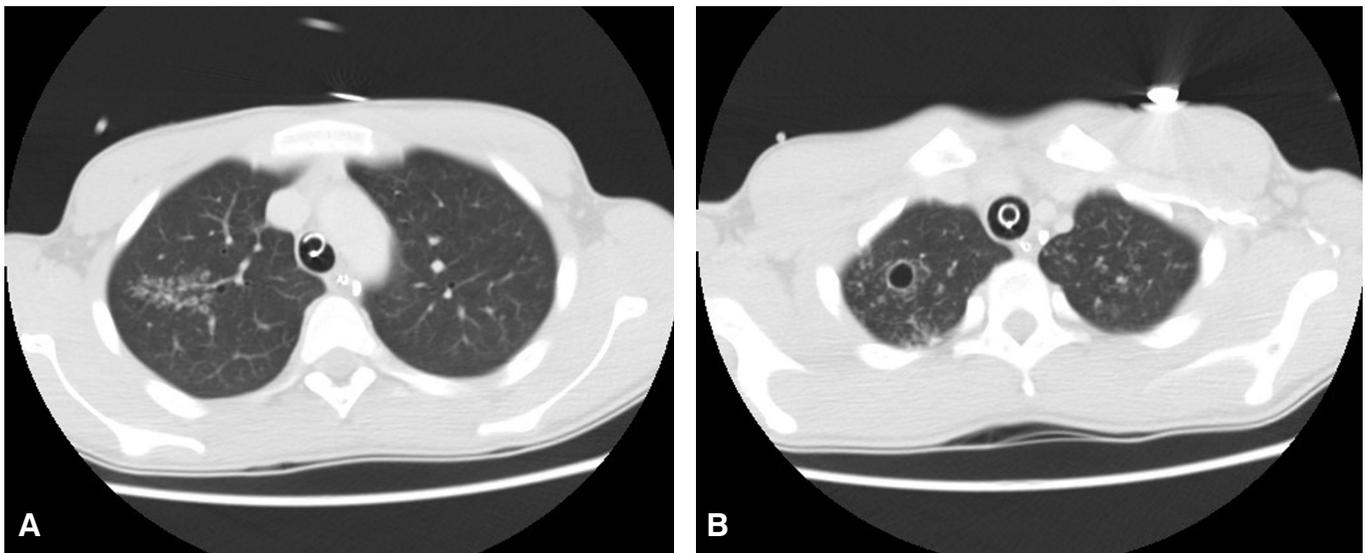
CT scans of the chest showing (A) reticular-nodular opacities, tree-in-bud opacities and (B) cystic bronchiectasis mostly involving the right lung.
